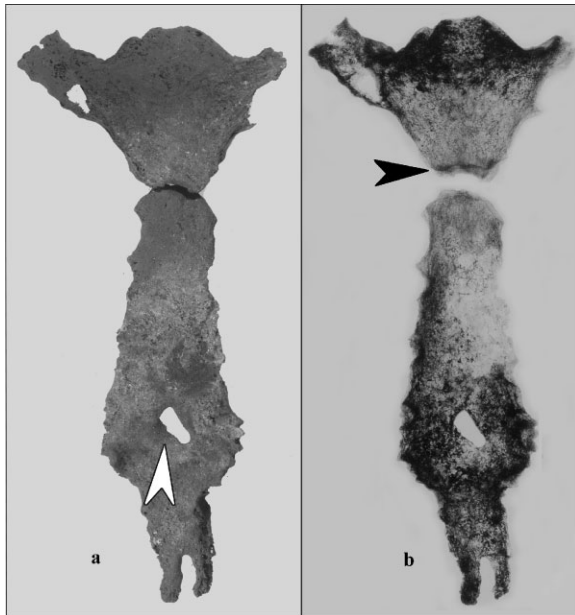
(a) Photograph of sternum (white arrow marks area of thinning as noted in text) and (b) anterior-posterior radiograph of sternum (black arrow marks formation of radiodense bone at altered manubrium and gladiolus articulation as noted in text).
